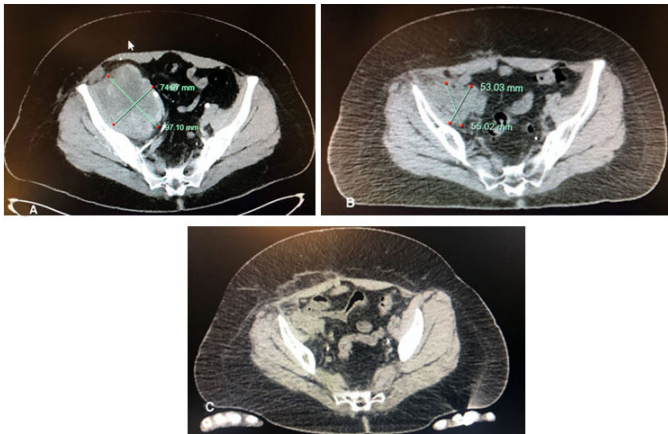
PET/CT evaluation of patient with cervical adenocarcinoma. (A) The initial scan demonstrated a large pelvic mass, with bidimensional measurements of 9.7×7.5 cm SUV 17.2. (B) After cisplatin/paclitaxel chemotherapy plus bevacizumab and concurrent radiotherapy there was improvement in the pelvic mass to 5.5×5.3 cm with persistently increased SUV 3.2. (C) Following 10 cycles of pembrolizumab there was no longer a measurable mass and SUV was reduced to background level.
